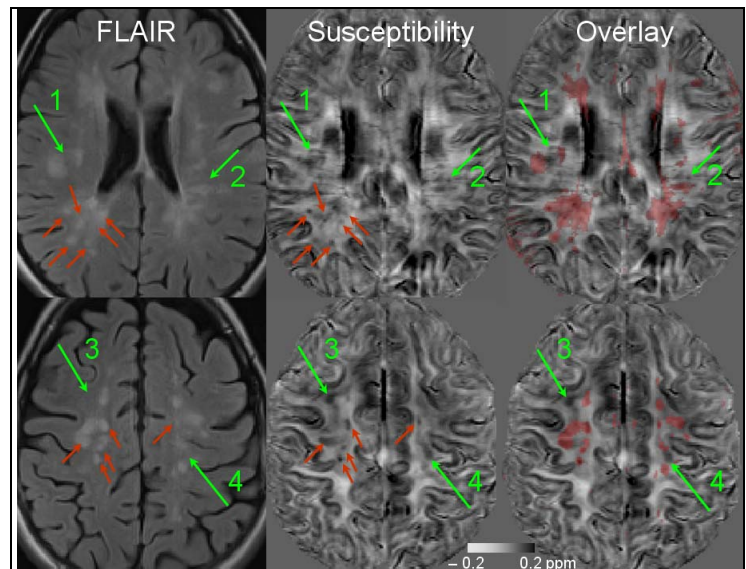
Susceptibility offers improved localization and higher sensitivity to MS plaques. Green arrows: 4 examples of plaques detected by susceptibility only (dark spots in the WM). Red arrows: examples of common lesions (dark spots in susceptibility). Overlay: FLAIR lesions (transparent red) are overlaid on susceptibility map for co-localization of lesions.
